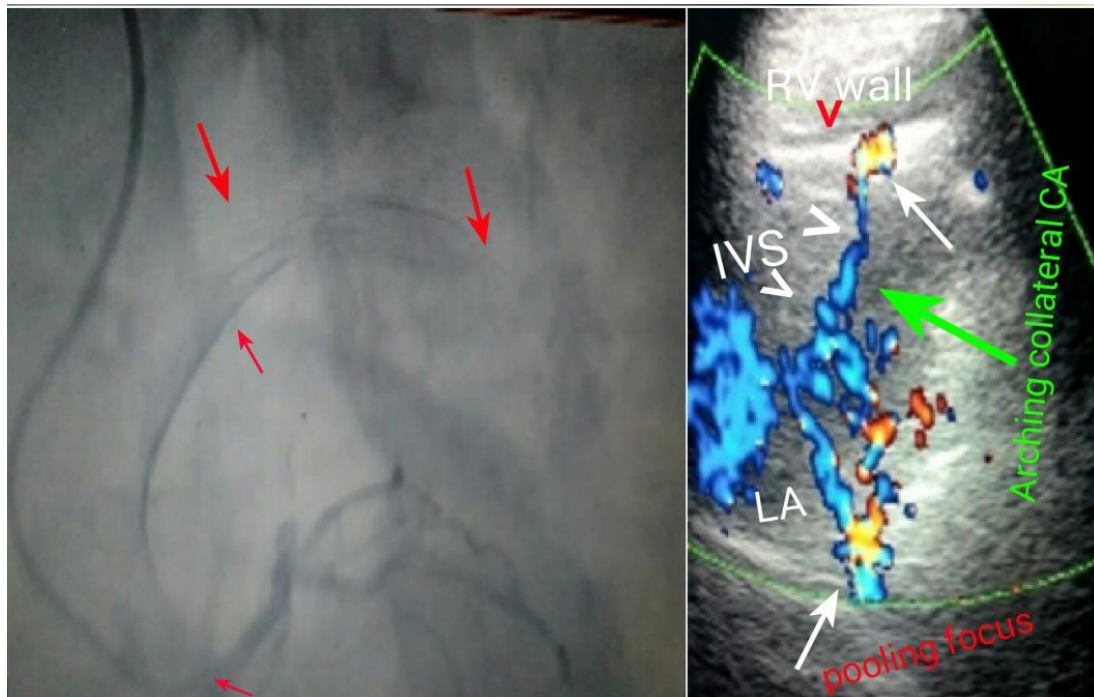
two views; right, for left main stem CA catheterization, it shows arching of multiple coronary arteries that arises from point pre to the main bifurcation, and extended in an arc shape to the pre apex level (red arrows), left is for long apical parasternal color flow echogram; it shows the same arteries in blue color which extended from a structure like a swirl (blue gathered vessels) that has bifurcates to basal and anterior divisions (arms), the basal one's connecting to blood pooling focus (red-orange color), which has six opening (white arrow; pooling focus); four at the level of the upper left atrium surface, one's that joined with the basal arm, and last one was connected with blue vessel segment that joined with smaller B.P Focus, then to blue vessel near the anterior arm, and both vessels (green arrow) joined with another pooling focus anteriorly (upper white arrow).
